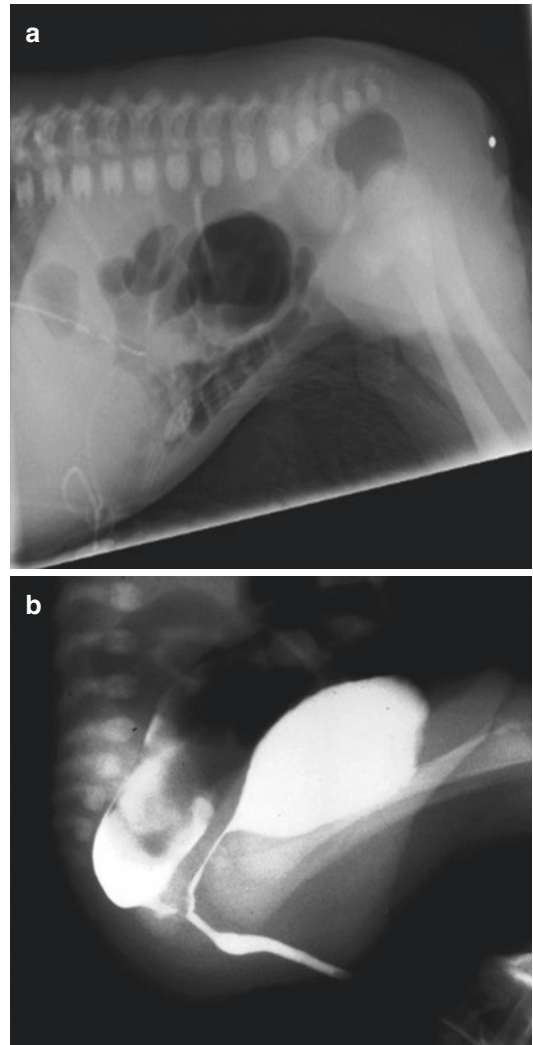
Diagnostic imaging for operative planning for repair of anorectal malformations: (a) Cross-table lateral radiograph, high rectum. (b) Distal colostogram showing a rectourethral bulbar fistula. Reprinted with permission from [6] © 2012 Elsevier
